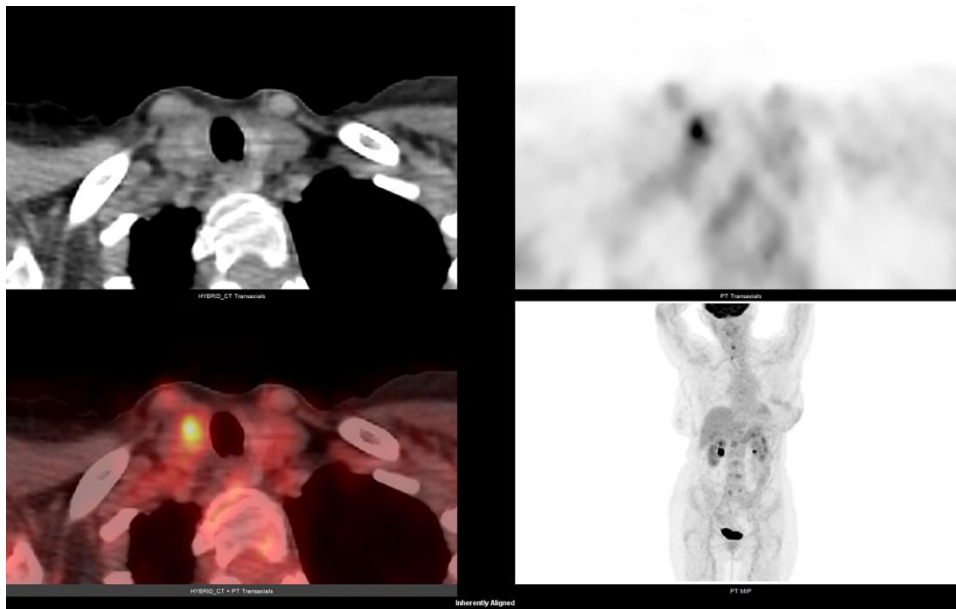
This is a case of focal thyroid FDG uptake in a 79-year-old female who underwent PET scanning for known laryngeal cancer. This revealed a 1.1 cm thyroid lesion in the right lower thyroid pole, SUV 6.0.
